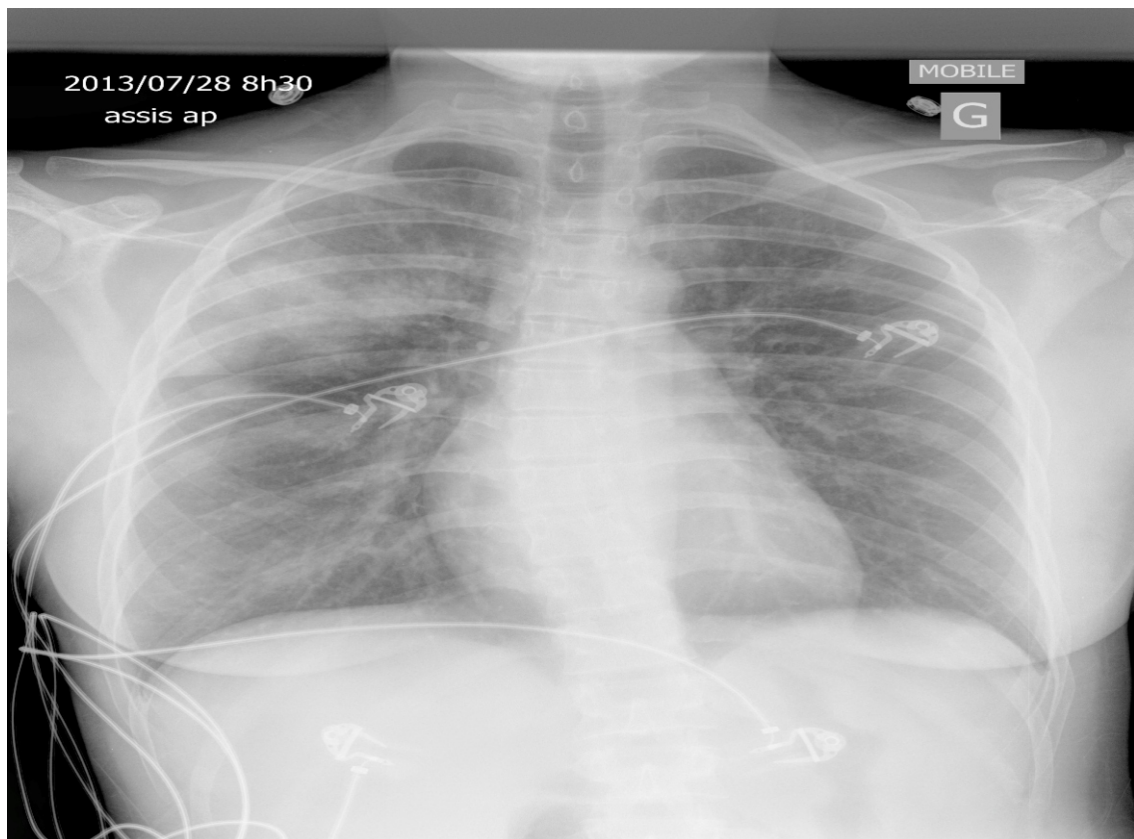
(28-07-2013 8h30am) Chest radiograph showed alveolar infiltrates within the right upper lobe.
